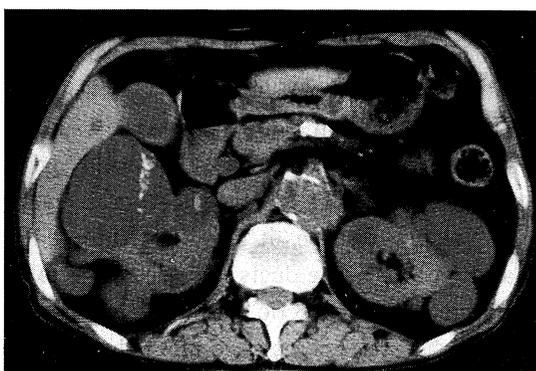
Unenhanced computed tomography of the kidney demonstrated multiple cysts with calcification of septal wall.
